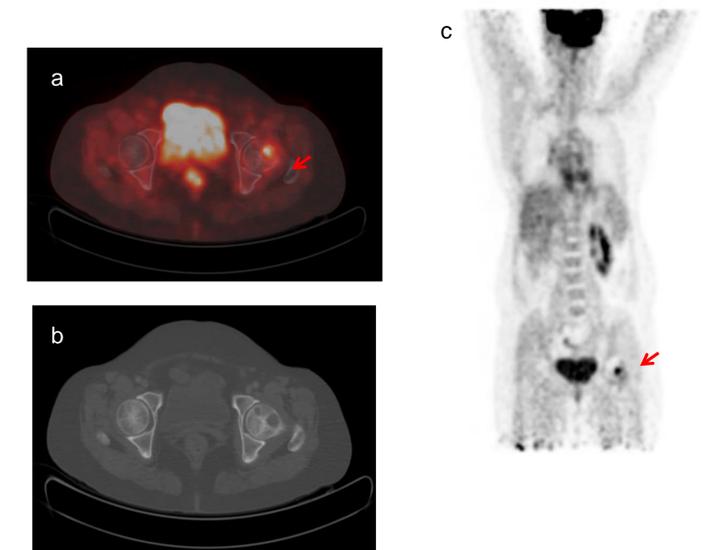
Re-staging scan of a 59 year old female after transplant, a metastatic lytic lesion in left femoral head in fused axial (a), CT only axial (b) images. No hepatic lesion is seen in PET only image (c).
